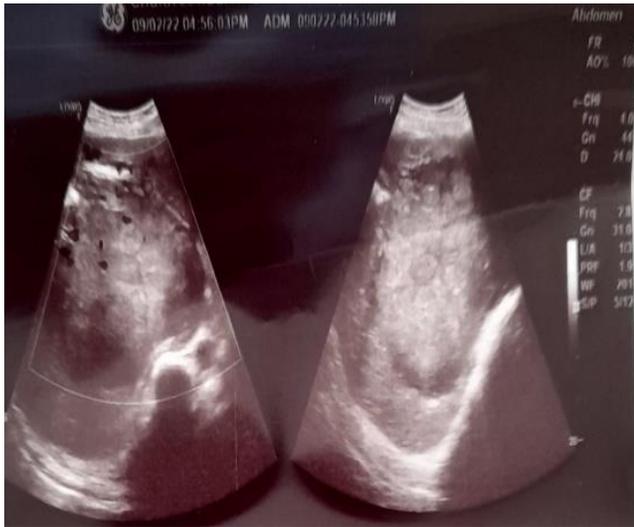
Doppler ultrasound
